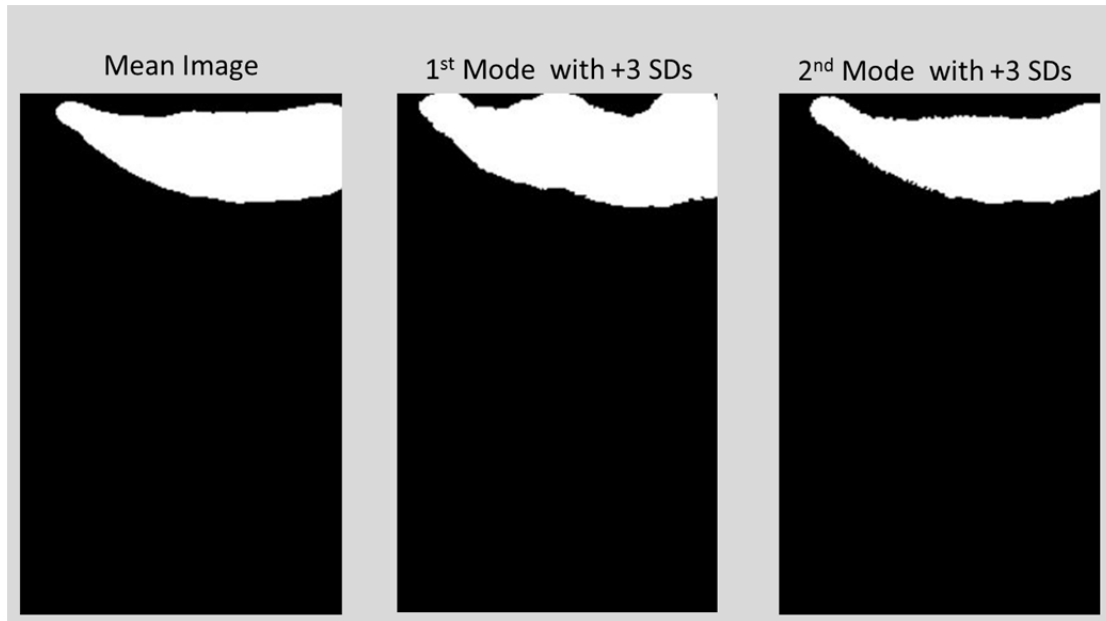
Example of the statistical shape model created from intersection of a tracked ultrasound slice with a co-registered MR tumor, showing the mean image (left) and three standard deviations of the first and second modes (middle and right).
